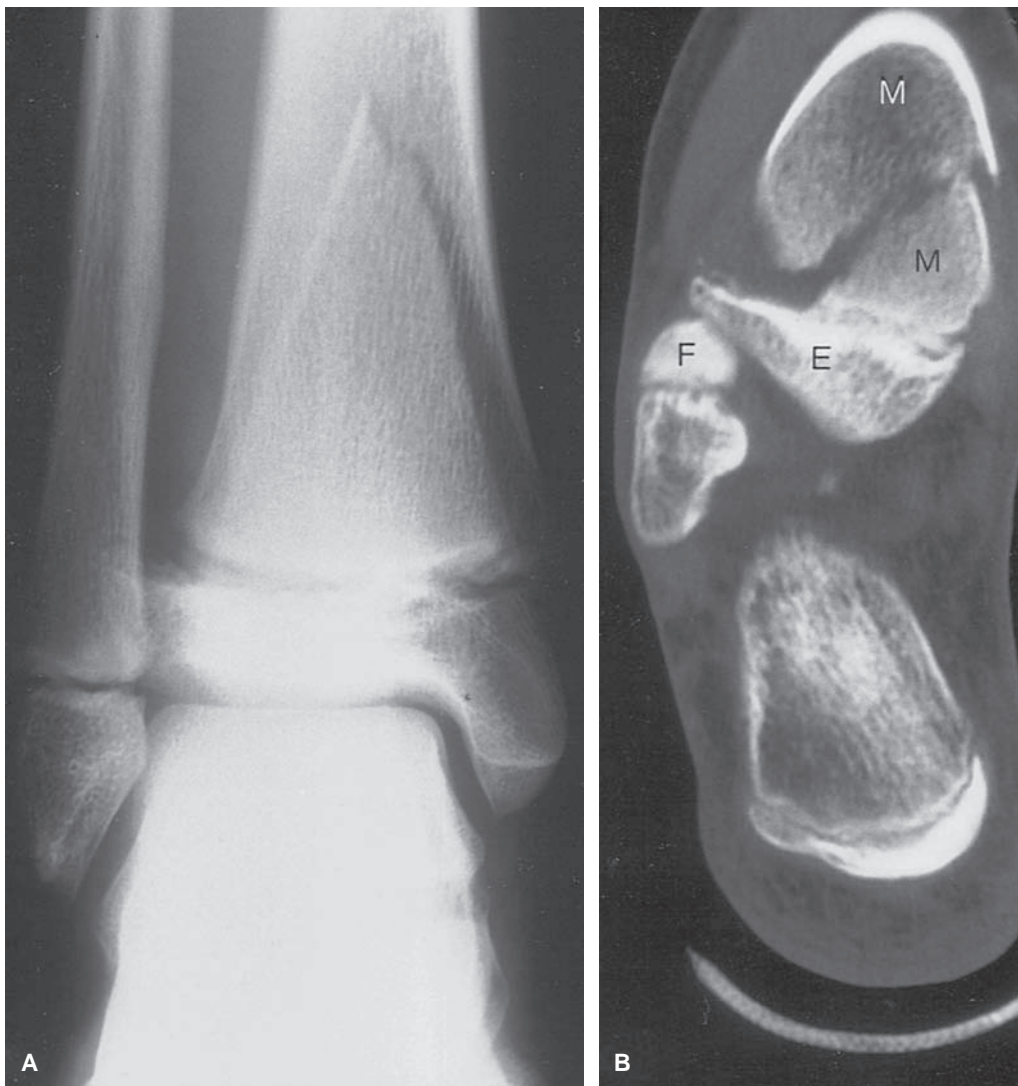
A: A triplane fracture was suspected from the plain film of the right ankle of this 11-year-old girl, although no clear epiphyseal fracture line could be seen. B: The coronal computed tomography scan made it possible to establish that the injury was indeed a Salter-Harris type II injury rather than the triplane fracture suspected. The fracture line runs laterally along the growth plate. E, epiphysis; F, fibula; M, tibial metaphysis.
